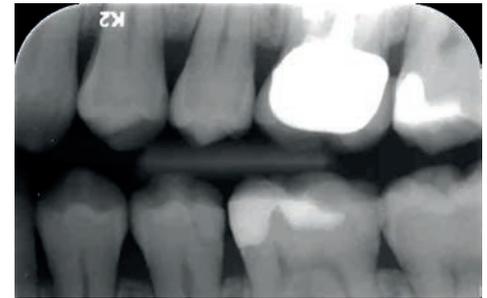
Case two – bitewing post-fit final crown
